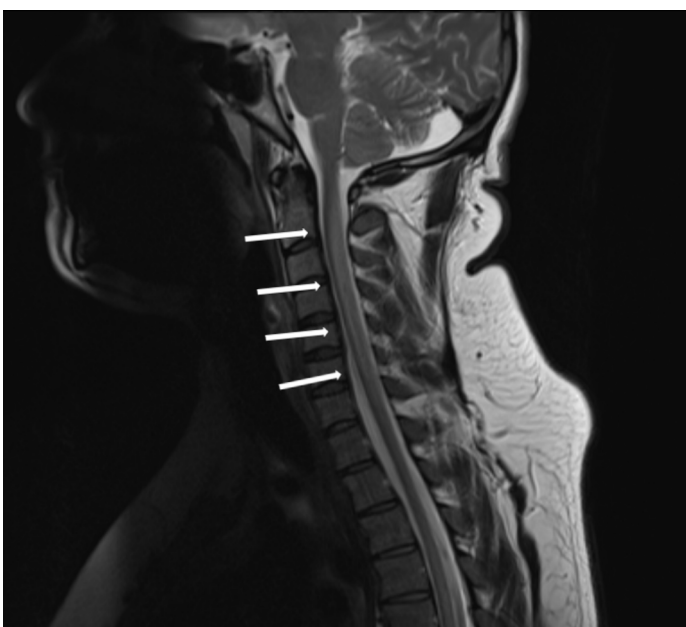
Sagittal T2-weighted image of the cervical spine showing a hyperintense signal from C2 to C6 within the spinal cord (arrows)
